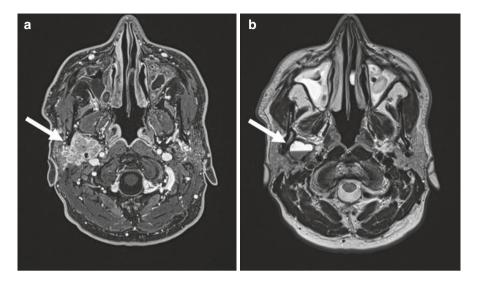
MRI examination of high-grade neoplasm located in the deep lobe of the parotid gland. On post-contrast T1W-FS sequence (a) the lesion shows inhomogeneous enhancement and irregular borders; on T2W sequence (b) the same lesion shows cystic component with fluid-fluid level within
